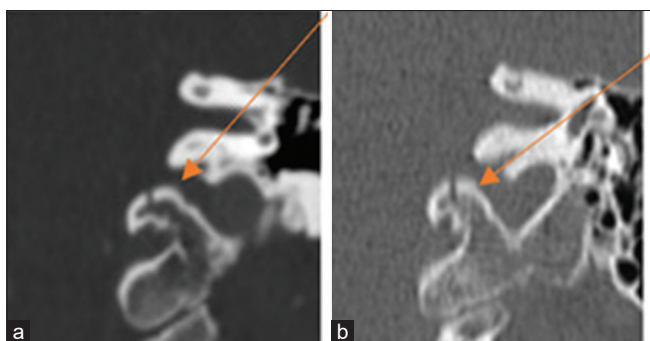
(a) A 42-year-old female motor cycle crash (MCC) with left Type II occipital condyle fracture with concomitant TBI, GCS 7T. (b) One-month interval CT cervical spine – a 42-year-old female MCC with left Type II occipital condyle fracture with concomitant TBI, GCS 7T with early signs of cortication of fracture line.
